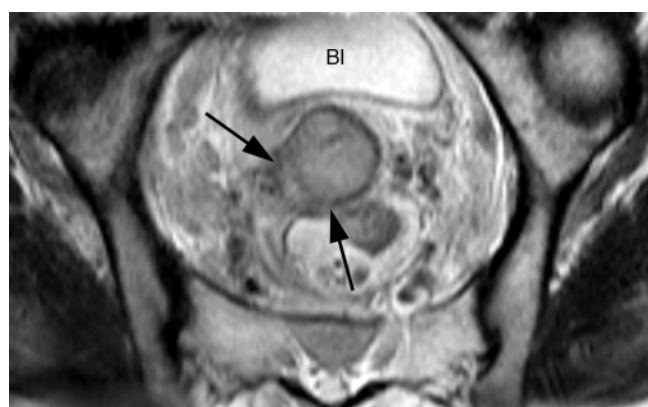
Cervical carcinoma with parametrial invasion. Oblique transverse T2-weighted ETSE image obtained perpendicular to the cervical canal (short-axis view) shows parametrial extension of tumor with disruption of the hypointense ring of fibrous stroma (arrows). The short-axis view of the cervix minimizes partial volume effects and may improve staging accuracy. (Bl = bladder.)
